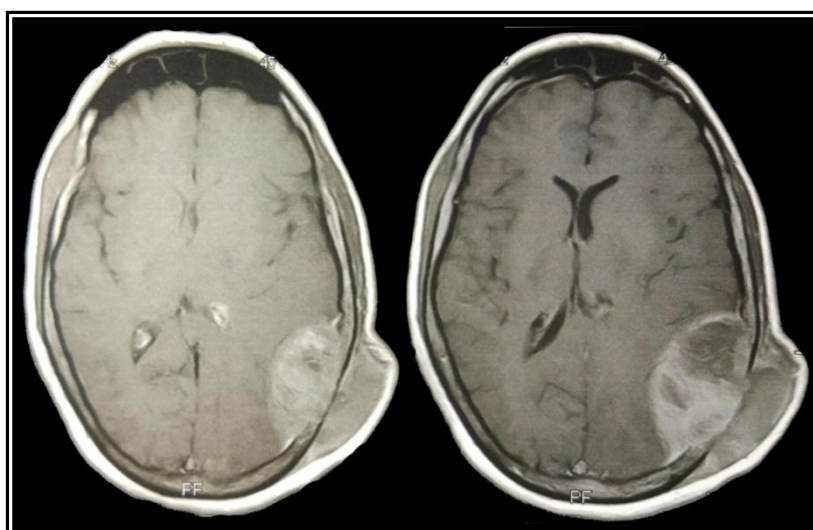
Axial MRI brain showing metastatic HCC eroding the bone
